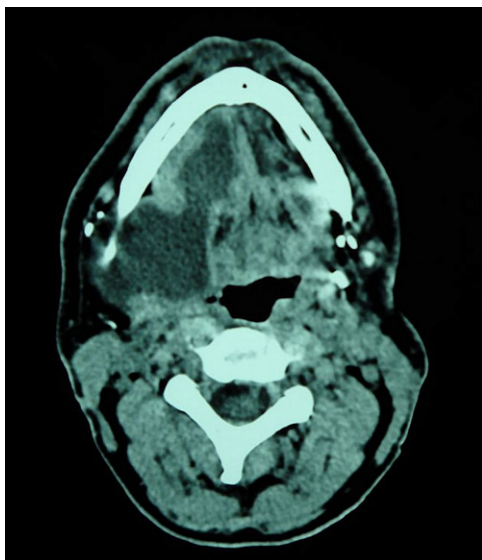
Computer Tomography (CT), axial view. A low-attenuation collection (mucoid) in the submandibular-lateral pharyngeal region in continuity with the sublingual space.
